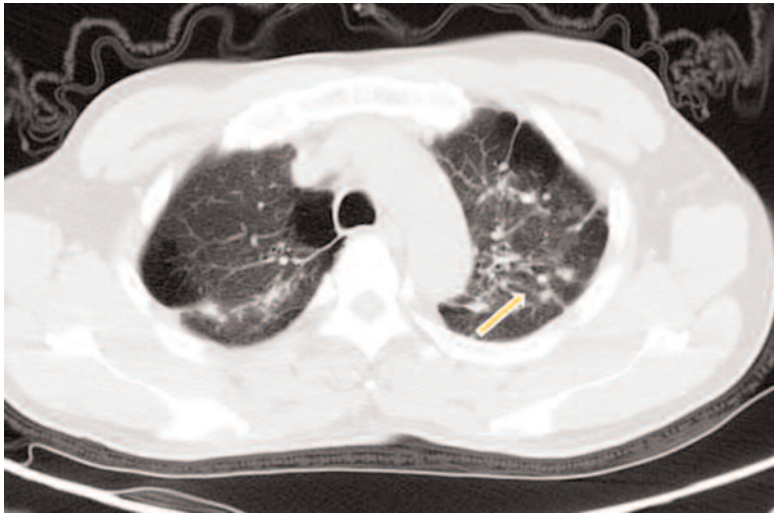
Chest CT scan shows bilateral upper segments small nodules in the 53-year old man with pulmonary tuberculosis.
